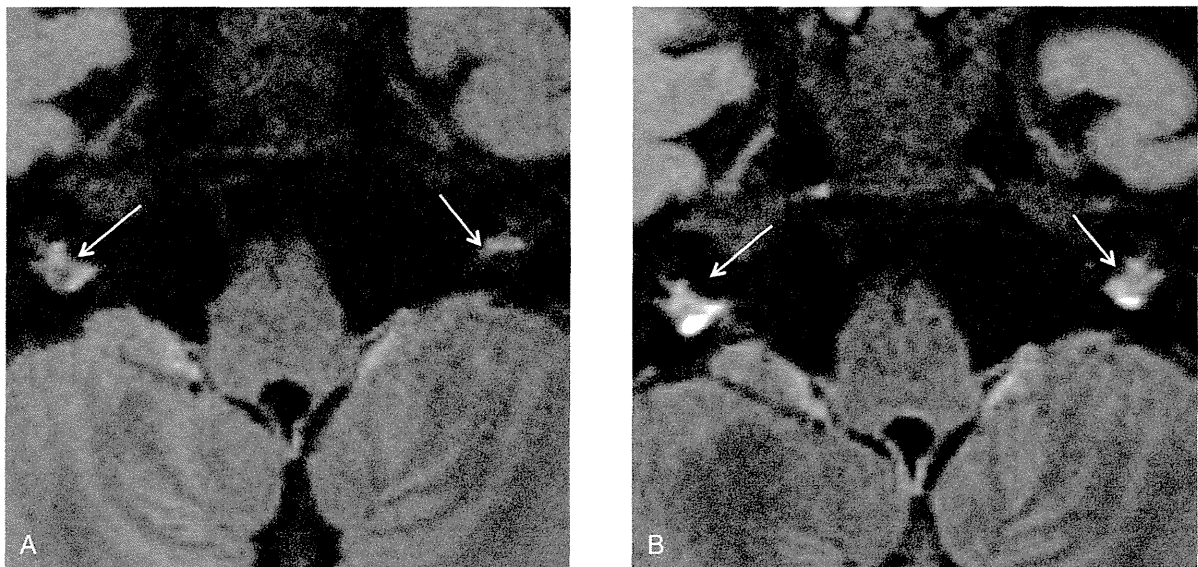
3D-FLAIR MRI after intravenous gadolinium administration. A was taken when she was 8 years old, and B was when she was 11 years old. The gadolinium enhancement of the internal auditory canal indicated by arrows was stronger in B than in A.
